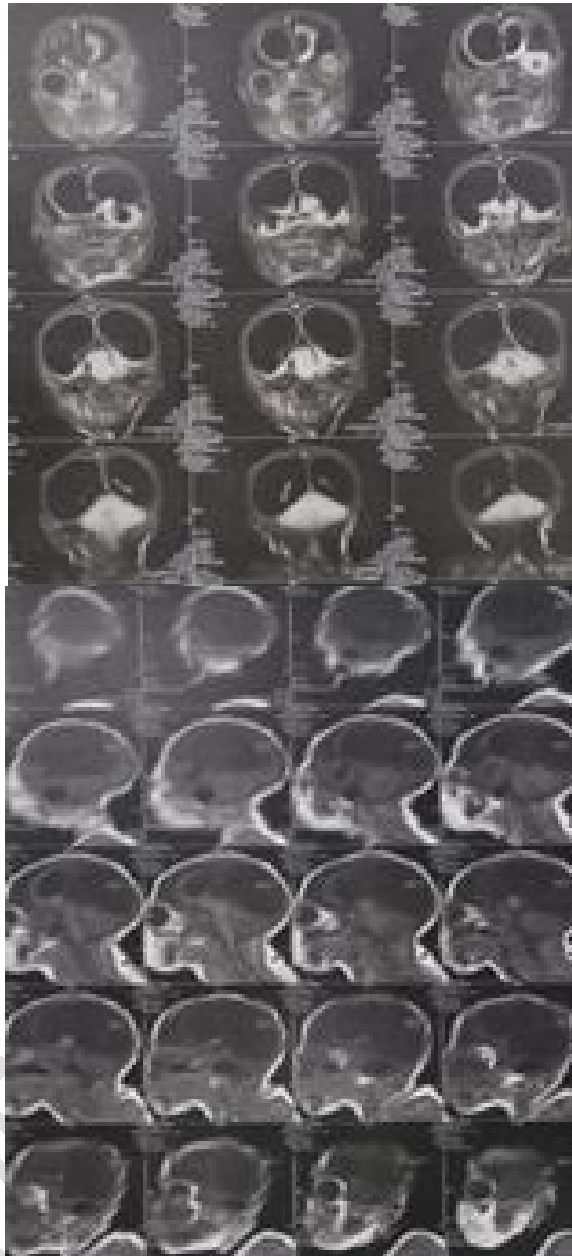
brain MRI indicative of hydranencephaly with bilateral frontal cystic encephalomalacia lesions
